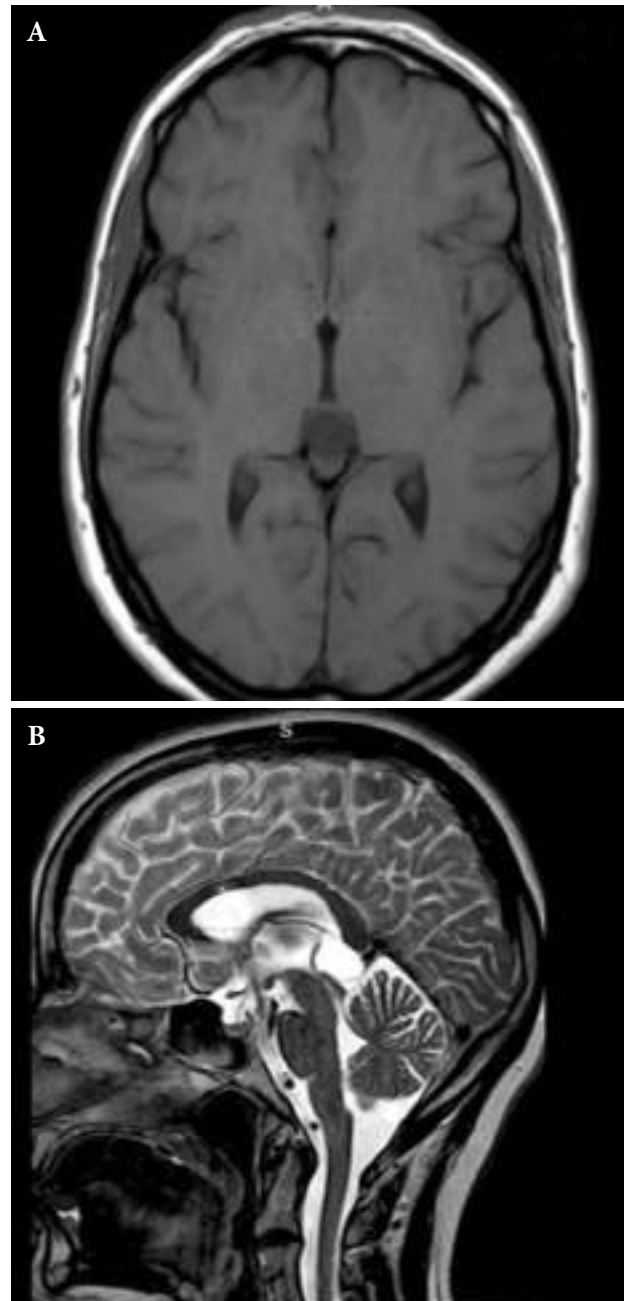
MRI images obtained at 3-month follow-up (A: axial T1-weighted; B: sagittal T2-weighted) demonstrating postoperative changes, including reduced ventricular dilation and decreased size of the cystic lesion.
